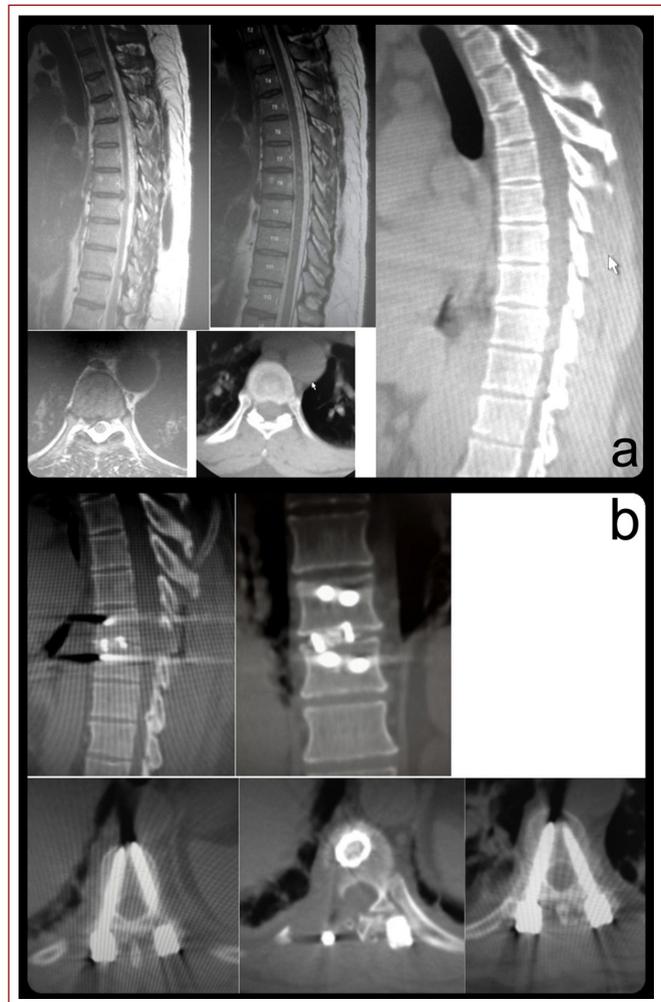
a) Preoperative MRI and CT images showing lateral disc hernia at the T8-9 level; b) postoperative CT images of the same patient.
